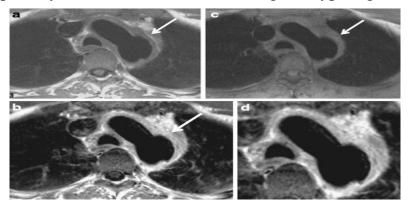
Magnetic resonance angiography in Takayasu arteritis: Spin-echo T1-weighted (a), post-gadolinium enhanced (b) and proton density (c) images of the aortic arch show diffuse and relatively uniform thickening of the aortic arch with focal aneurysmal dilatation
